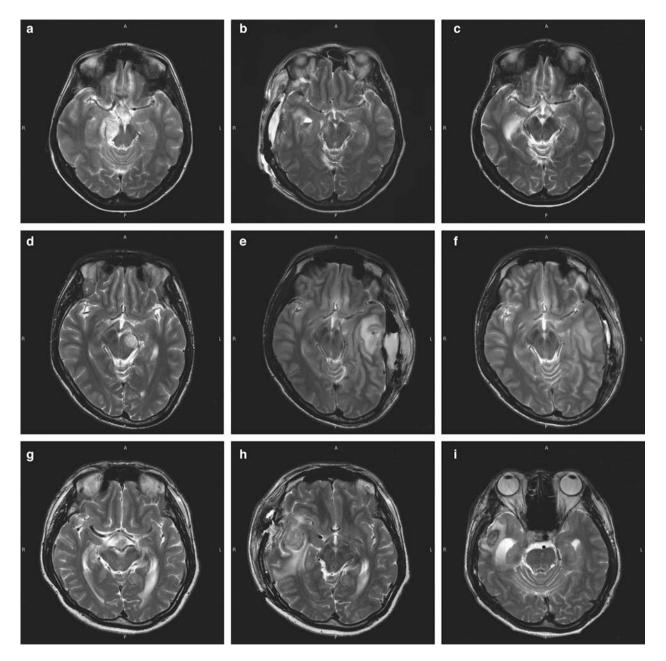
T2-weighted magnetic resonance imaging (MRI) at the level of midbrain in patients operated on via the transpetrosal approach, in whom permanent signal intensity changes were observed postoperatively. *Left column*: preoperative baseline images. *Middle column*: images at 72 h after surgery. *Right column*: images at long-term follow-up. *Upper row* (Case 39): after surgery for right-side petroclival meningioma (a), a small intraparenchymal hemorrhage was observed in the right temporal lobe (b) and remained at long-term follow-up examination (c). *Middle row* (Case 45): after surgery for left-side petroclival
